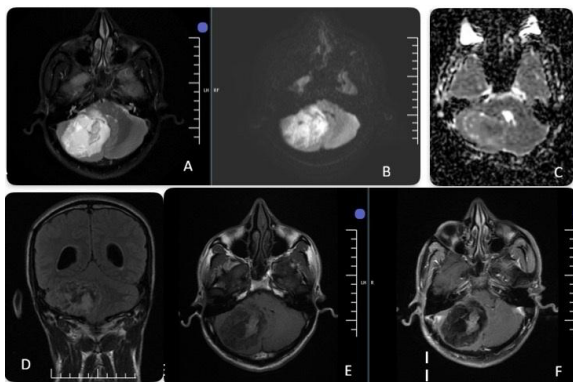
MRI brain(plain with contrast) from 2014 showing presence of epidermoid cyst in right CP angle
